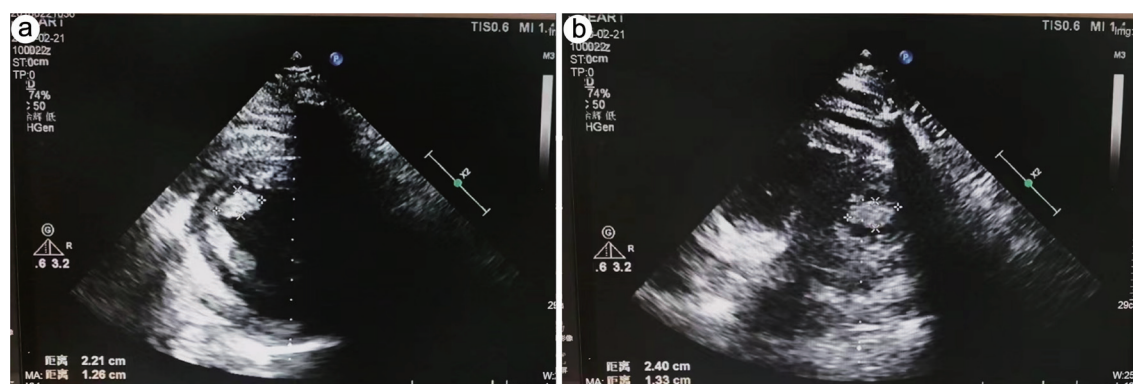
Rechecked UCG of case 2. UCG, ultrasonic cardiogram.
